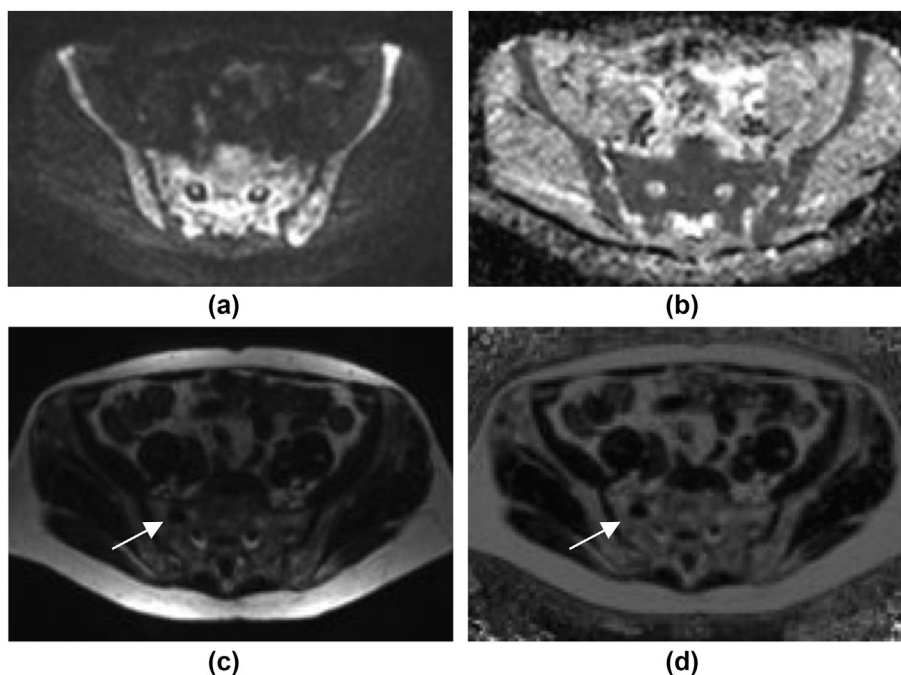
Diffuse marrow hypercellularity obscures focal lesions on DW-MRI. (a) Axial $b = 900 \text{ s/mm}^2$ DW-MRI shows diffuse abnormal high signal in the bone marrow and (b) impeded diffusion on the ADC map, which suggests diffuse hypercellularity. (c) Corresponding fat only and (d) FF map from Dixon MRI shows a focal lesion in the right side of the sacrum (arrows), which is not discernible on DW-MRI.
